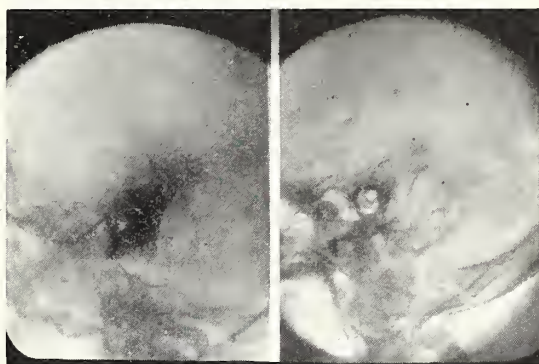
Case 2. X-ray of right mastoid compared with a normal right mastoid.
